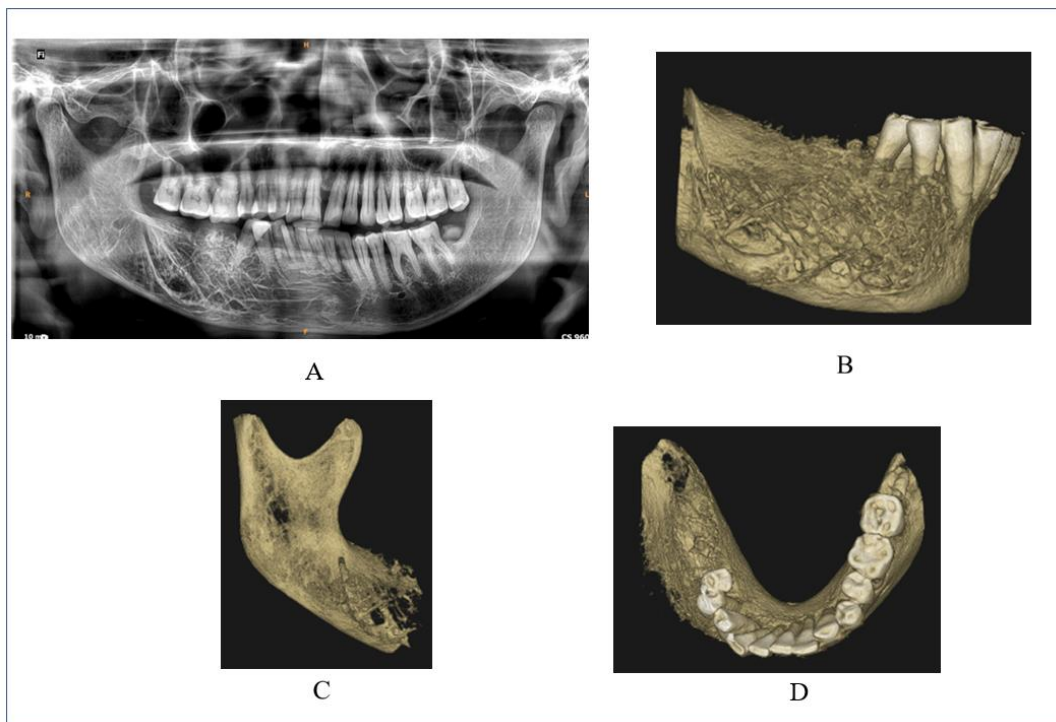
Preoperative radiographic evaluation. A Orthopantomogram; 3D rendered images of mandible: B buccal view of right posterior mandible. C buccal view of right ramus; D occlusal view
